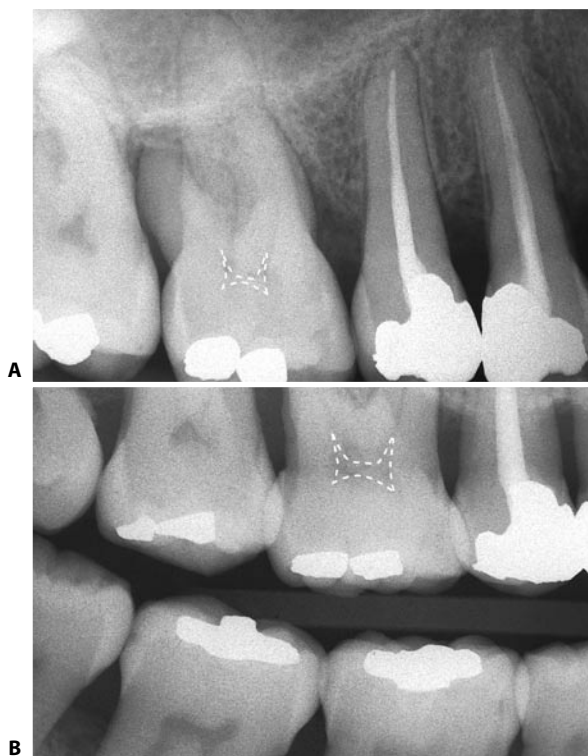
A. Preoperative radiograph of the maxillary first molar. The pulp chamber seems very calcified. B. The bite-wing radiograph shows the true dimensions of the pulp chamber.
